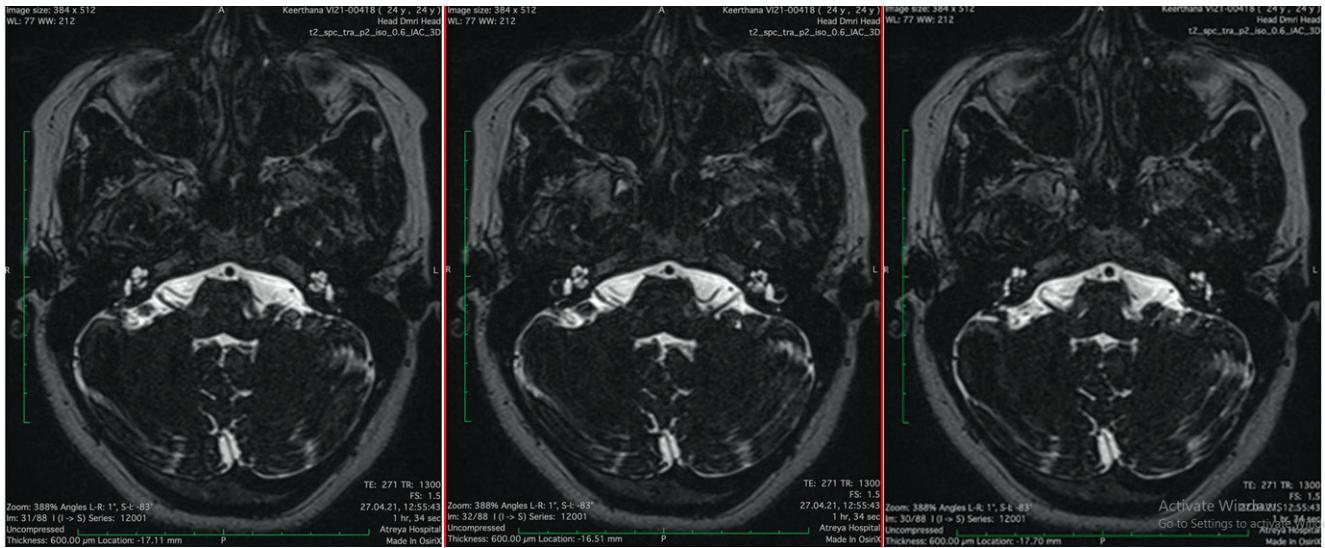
3T HR Axial MRI 3D CISS Sequence-Subsequent 3 Sections Showing Multiple Vascular Looping in the Bilateral 7th/8th Nerve Complex more on the Right Side
